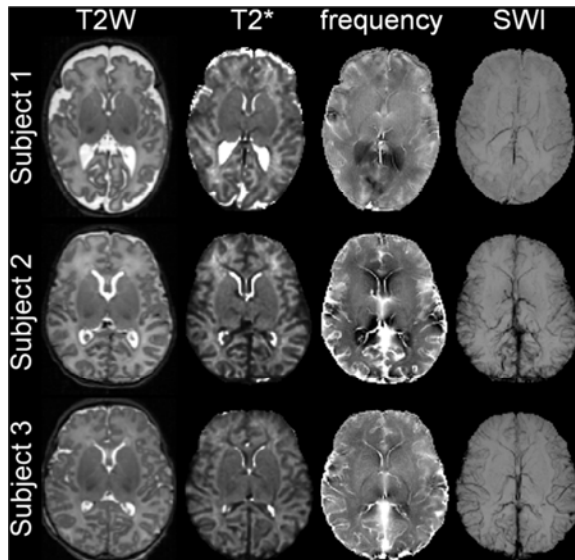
Comparison of clinical T2-weighted images and GEPCI-derived multi-contrast images (T2*, frequency and SWI).
